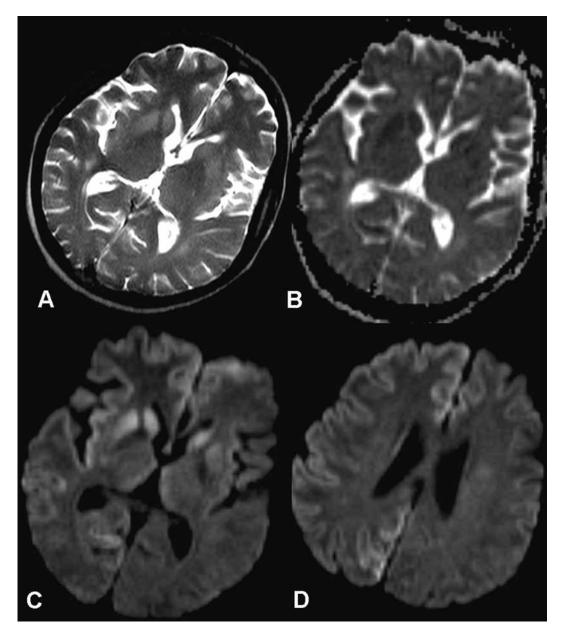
Magnetic resonance images in axial plane. A: T2-weighted image shows bilateral hyperintensities in caudate nuclei and putamina, corresponding to areas of low apparent diffusion coefficient on ADC map, shown in B. C, D: Diffusion-weighted images show additional hyperintensities in right insular, occipital and parietal cortex, indicating restricted diffusion.
